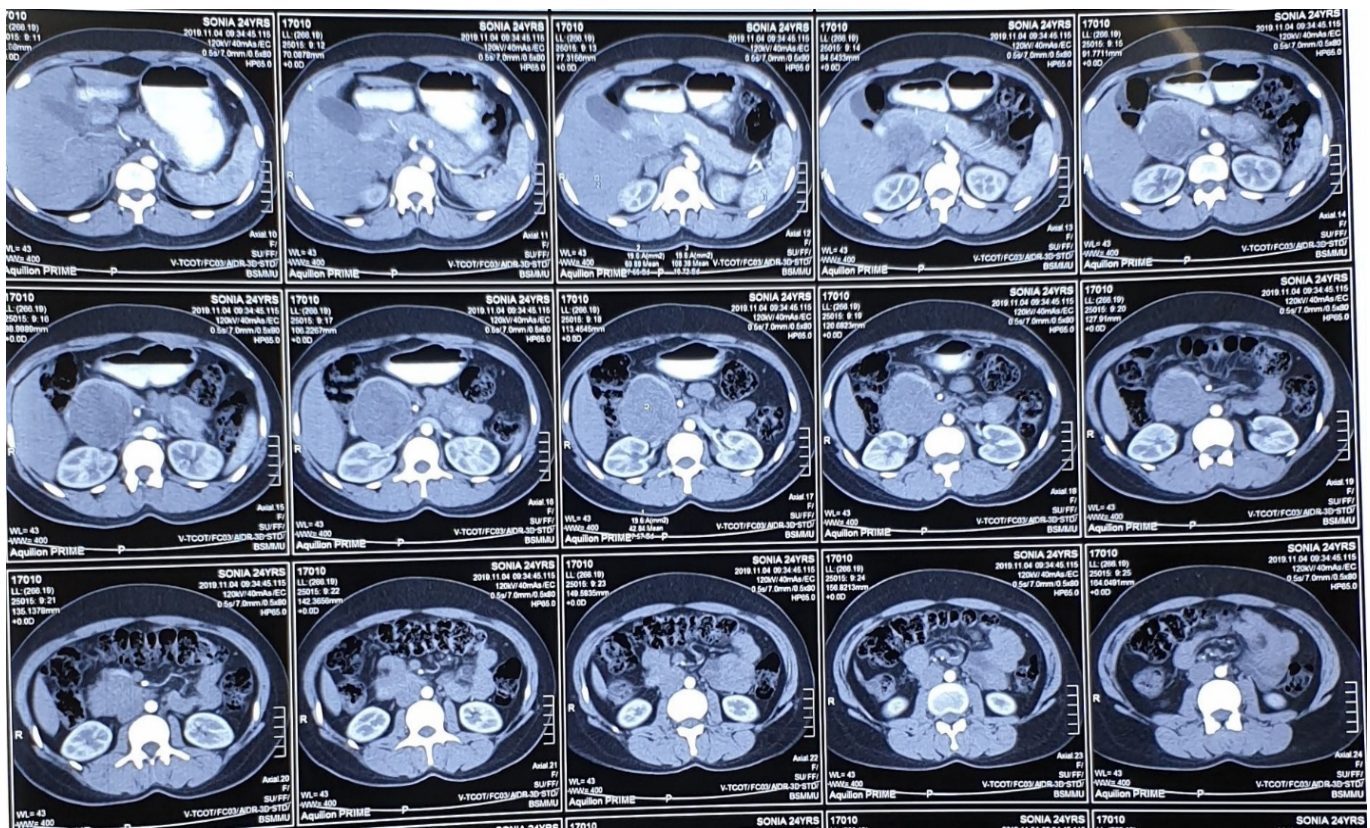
CT scan of a Solid Pseudopapillary Tumor
